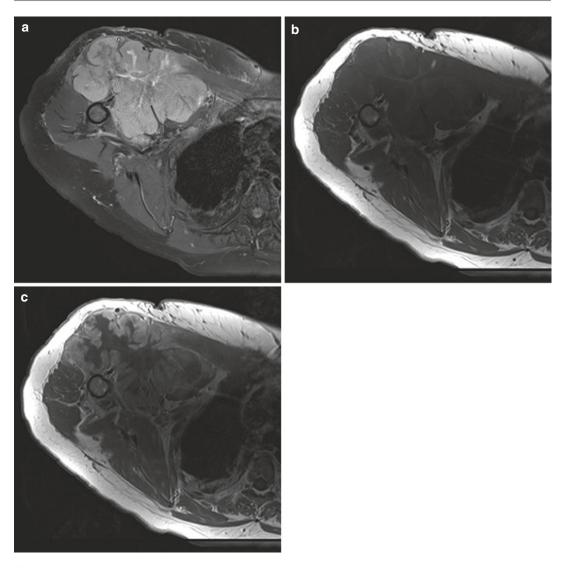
(a–c) Sclerosing epithelioid fibrosarcoma in the anterior soft tissues of the right shoulder (a) Axial T2-weighted MR image with fat saturation (b) Axial T1-weighted MR image (c) Axial post-contrast T1-weighted MR image. A large multilobulated mass is located in the pectoralis, biceps, and brachialis muscle bellies and abutting the humeral diaphysis. Fairly homogeneous lesion with intermediate signal on T2- and low signal on T1-weighted MR images. Thick, irregular band of enhancement is seen in the periphery of the lesion
